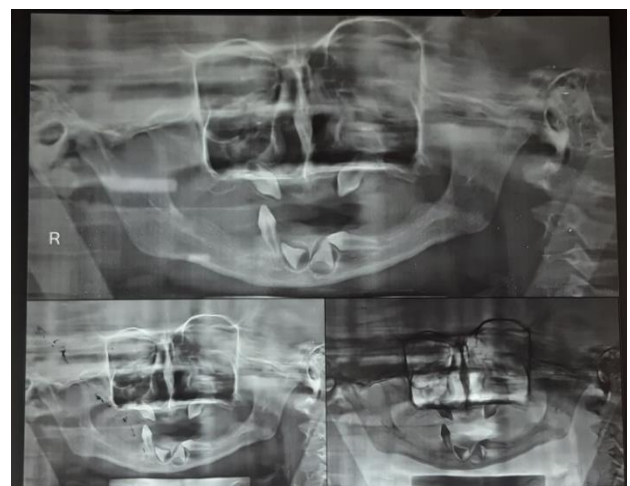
Orthopantomogram.
